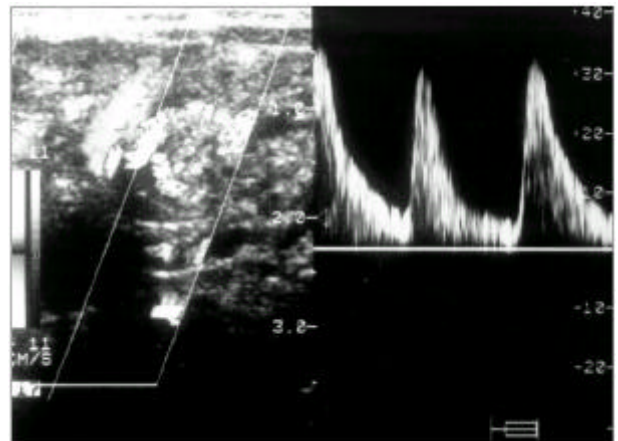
Ultrasonogram: “Whirlpool sign” characteristic of midgut volvulus with preservation of superior mesenteric blood flow.
